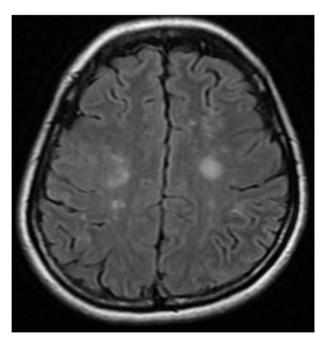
Brain MRI film. Multiple sites of cerebral infarction were identified. However, no brain metastasis was observed.
